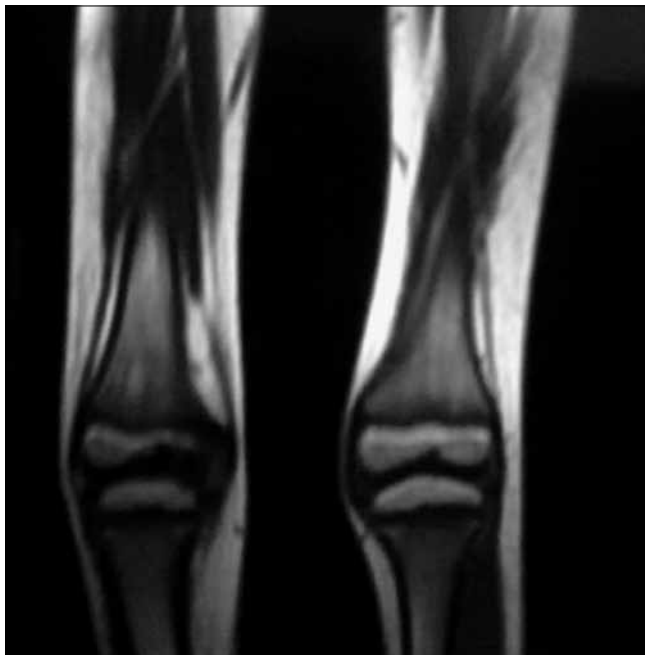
Bilateral knee on MRI.
